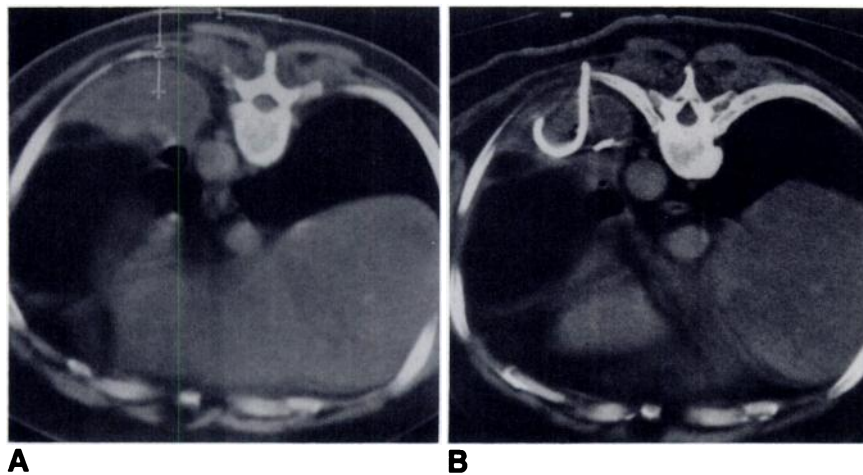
CT-guided drainage of loculated left pleural effusion. Patient is prone.
